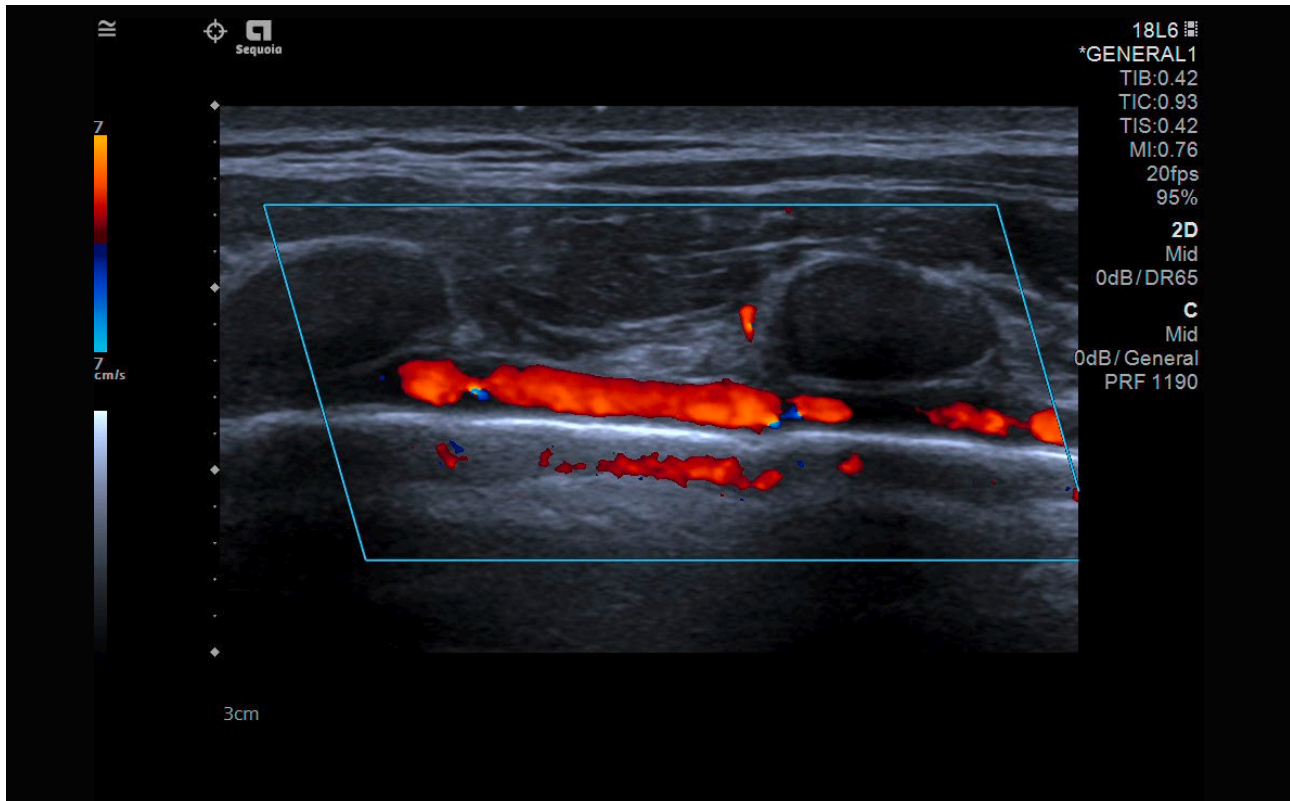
Anatomical basics of the chest wall structures and the internal thoracic artery using the color Doppler examination.
